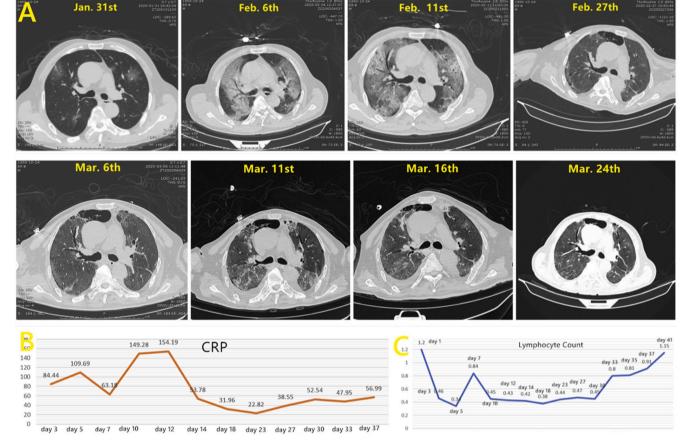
Fig. 4shows the representative image of a 66-years-old man who had a fever, cough, dyspnea and rapid progressions of both pulmonary ground-glass opacities and consolidation. CT scans were performed once a week to two weeks from admission to discharge. (A). With the decline of CRP(B) and increase of lymphocyte count(C), his chest CT imaging improved. The peaks of both CRP and lymphocyte count emerged almost simultaneously, corresponding with the worst CT images, which occurred in the second scan (A Feb.6th) and the third CT scan (A Feb. 11th).
